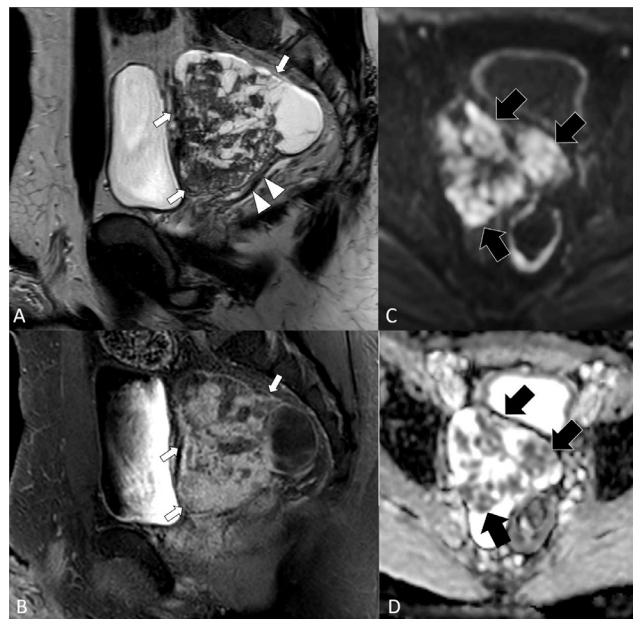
Thirty-nine year old male with solitary fibrous tumor. Findings: 3 Tesla MRI of the pelvis. Sagittal T2WI (A) shows a lobulated solid and cystic mass (white arrows) posterior to the bladder closely abutting the seminal vesicles (white arrowheads)[Technique: Sagittal 2D T2WI Spin Echo, TR 4395, TE 100ms, 3 mm slice thickness]. Sagittal post contrast T1WI (B) shows enhancement of the solid components within the mass (white arrows) [Technique: Sagittal fat saturated T1WI Gradient Echo TR 3.18, TE 1.54 ms, 3 mm slice thickness, 10cc Multihance IV contrast]. Diffusion weighted imaging (C) and apparent diffusion coefficient map (D) show restricted diffusion in the solid components of the mass (black arrows) [Technique: Axial b1000 Diffusion weighted imaging TR 932, TE 58.88 ms, 5 mm slice thickness. Axial Diffusion coefficient map TR 932, TE 58.88, 5 mm slice thickness.]
